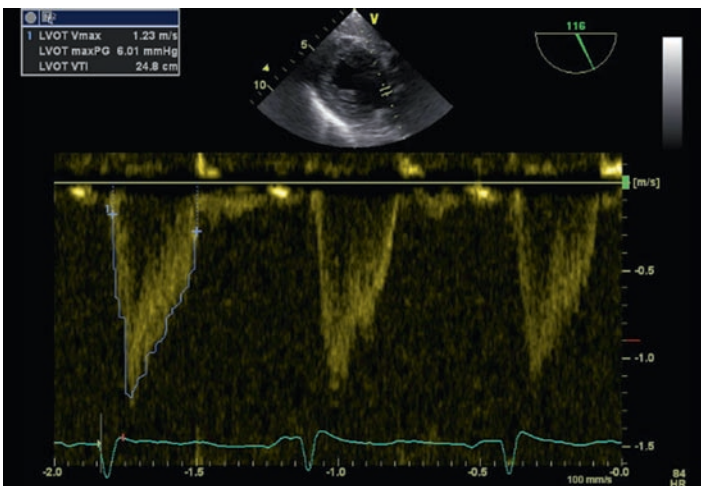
Left ventricular outflow tract (LVOT) pulse wave Doppler recording from the transgastric long axis view. LVOT velocity time integral obtained by tracing around the pulse wave Doppler profile (24.8 cm).
